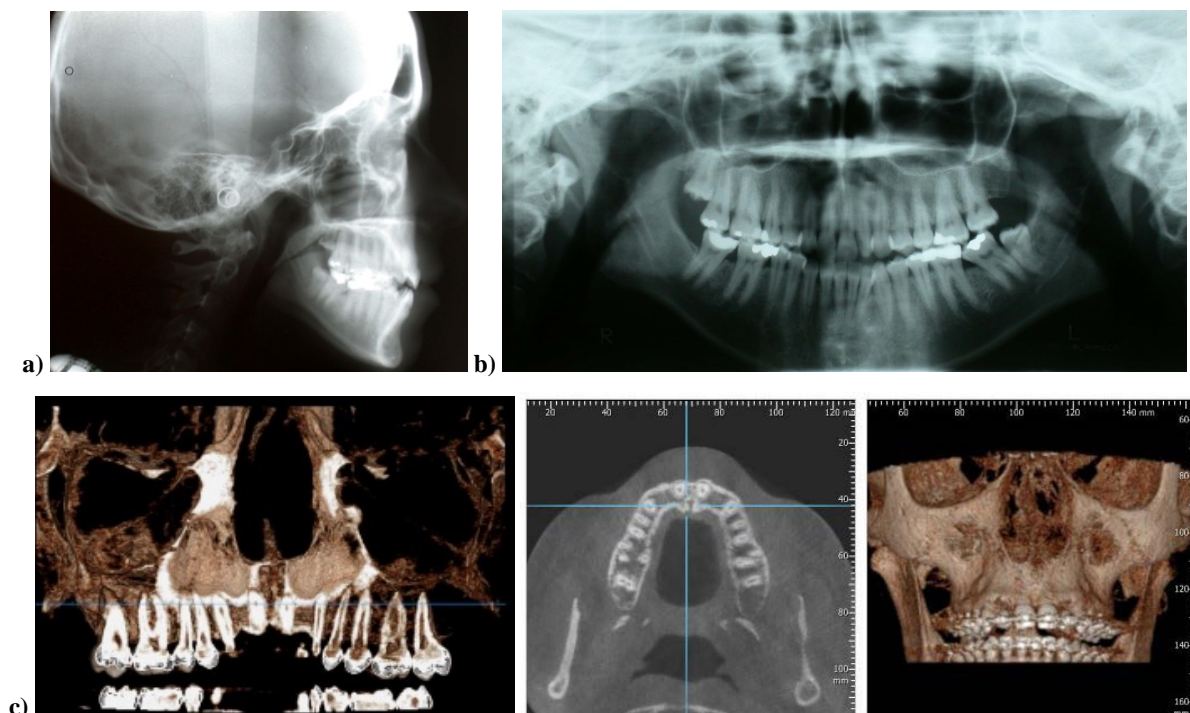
Pretreatment records: a) lateral x-ray; b) panoramic x-ray; c) upper Dentascan.
